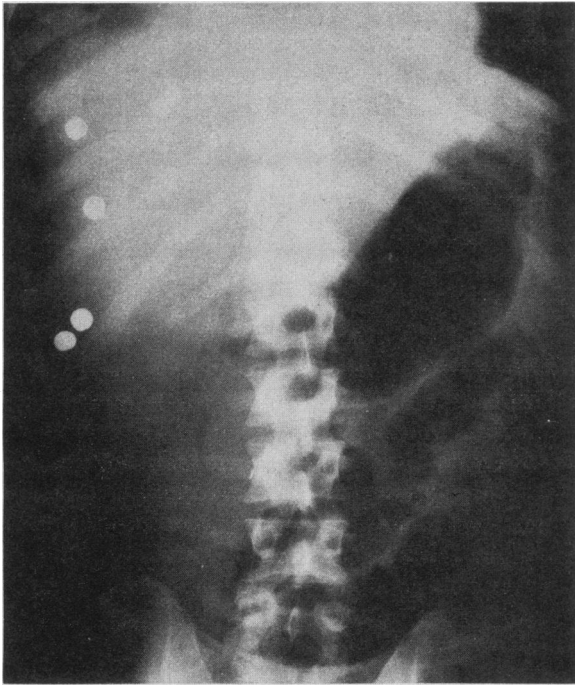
Roentgenogram showing intrathoracic buckshot.
